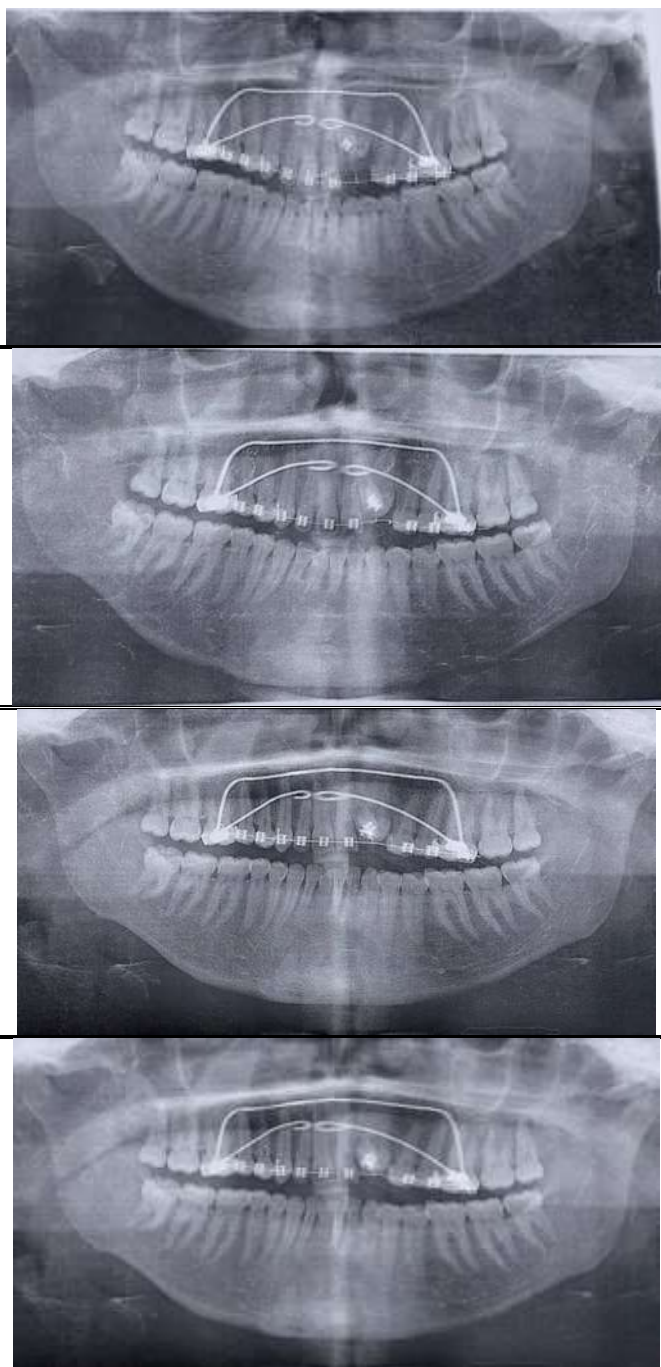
radiographic records taken during treatment.
